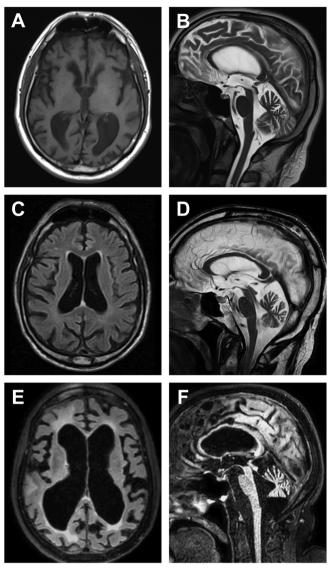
Representative brain magnetic resonance images showing global cerebral (A, C, E) and infratentorial (B, D, F) atrophy. (A) Patient 10, T1 weighted, axial. (B) Patient 10, T2 weighted, midsagittal. (C) Patient 07, fluid-attenuated inversion recovery (FLAIR), axial. (D) Patient 07, T2 weighted, midsagittal. (E) Patient 01, FLAIR, axial. (F) Patient 01, FLAIR, midsagittal.
